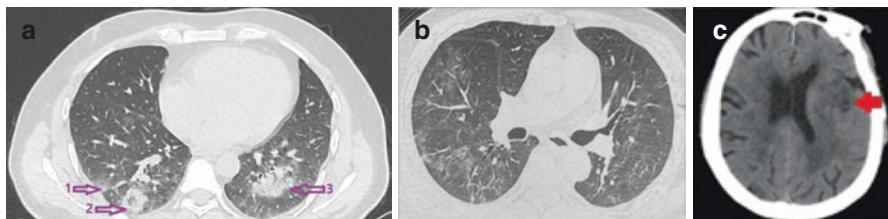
CT images of the chest and brain of COVID-19 male patients. (a) lesions to the patient lung have been identified in this study with a purple arrow. (b) CT images of the lung of a COVID-19 patient 1 day after stroke in another study [53]. (c) CT brain photo of the patient 1 day after a stroke [53]
